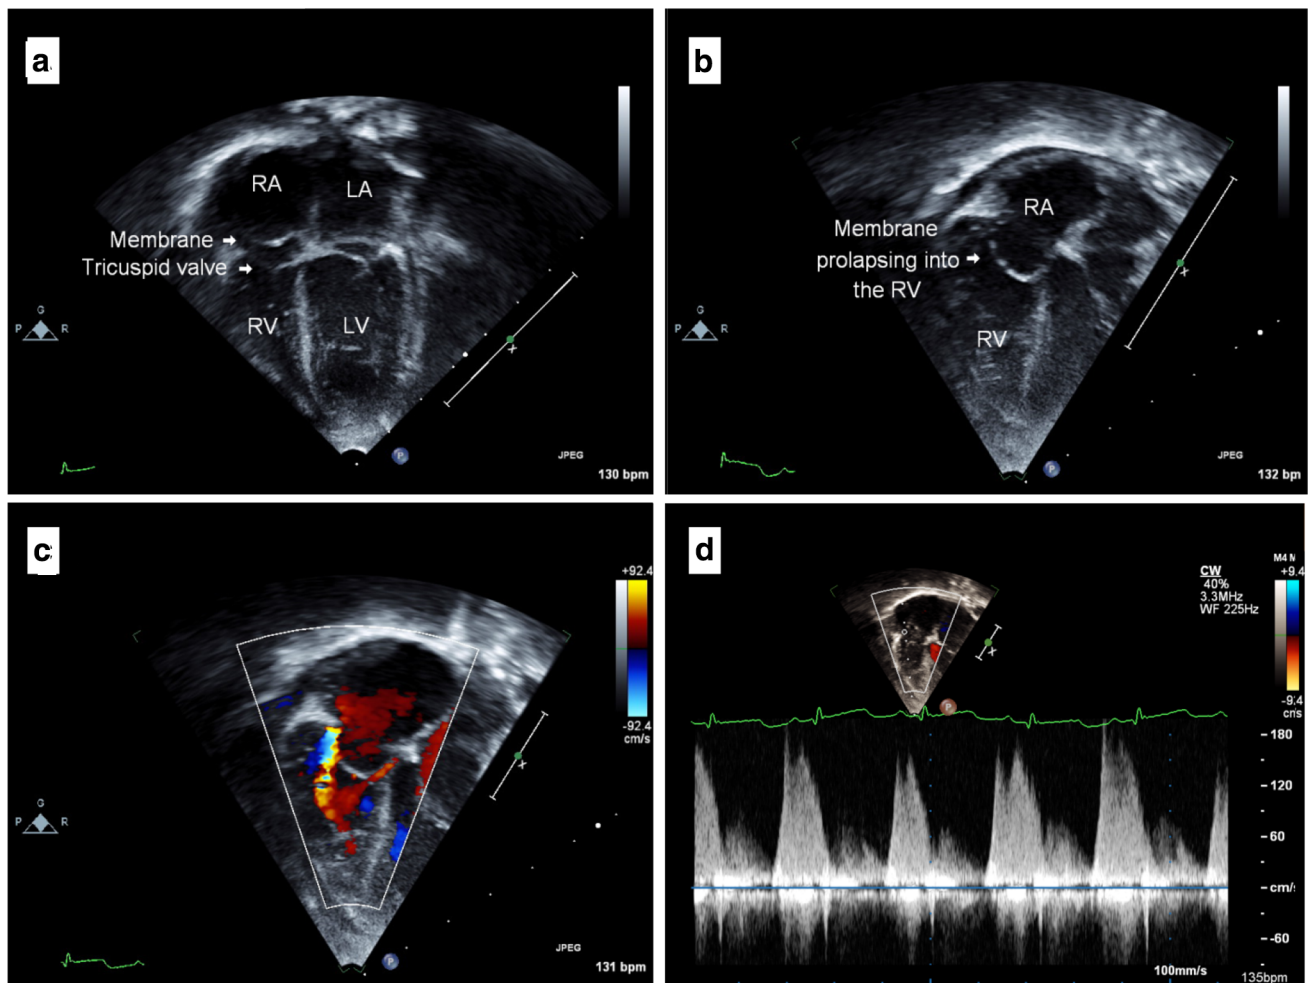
a Echocardiographic apical 4 chamber image during systole shows cor triatriatum dexter with the membrane positioned in the right atrium above the tricuspid valve. b Echocardiographic apical 4 chamber image during diastole shows the membrane prolapsing through the tricuspid valve into the RV. c Echocardiographic apical 4
